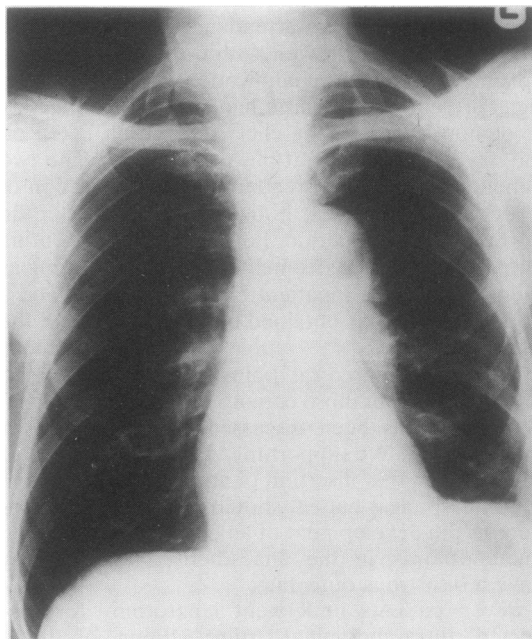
Chest radiograph three months after the decortication showing a satisfactory postoperative appearance.*
